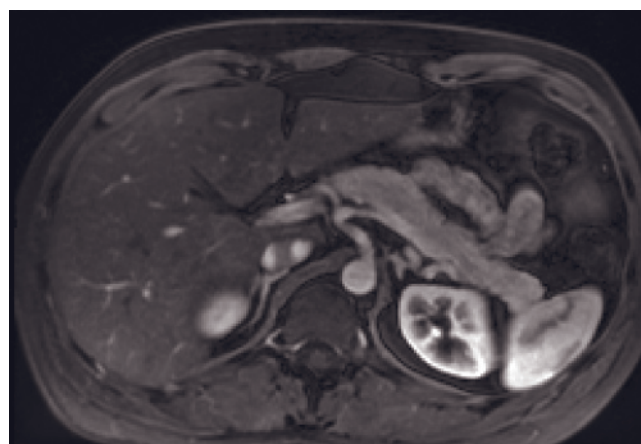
(Continued) and immediate (*i*) and interstitial-phase (*j*) postgadolinium fat-suppressed T1-weighted gradient-echo images of pancreatic body and tail in a second patient. The normal pancreas is high in signal intensity on T1-weighted fat-suppressed image (*b*) because of the presence of aqueous protein in the acini of the pancreas. A uniform capillary blush is apparent on the immediate postgadolinium image (*i*). Small bowel is moderate in signal intensity on T1-weighted fat-suppressed image (arrow, *b*), which is clearly different from the homogeneous or marbled high signal intensity of the pancreas. The normal-caliber pancreatic duct is well shown (arrow, *e*) on T2-weighted image.
